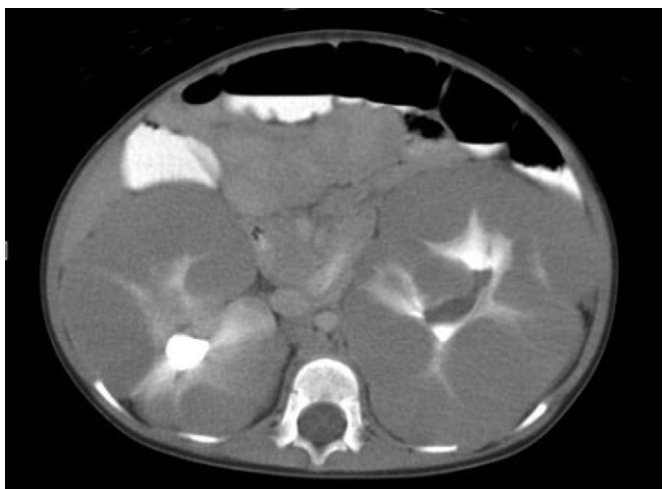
Computed tomography (CT) scans showing diffuse hyperplastic perilobar nephrogenic rests.
